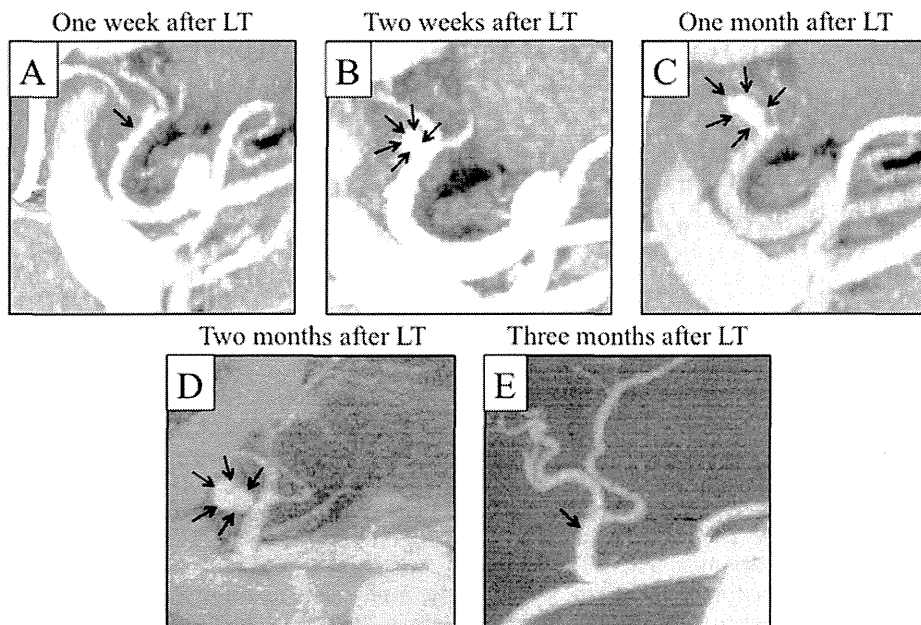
Development of a hepatic artery pseudoaneurysm as observed with dynamic computed tomography after LT. (A) One week after LT, there was no hepatic artery aneurysm. (B) Two weeks after LT, a tiny globular pseudoaneurysm was evident at the distal side of the anastomosis. (C) One month after LT, the pseudoaneurysm was developing as a spindle-shaped form. (D) Two months after LT, the pseudoaneurysm had grown to 7 mm in diameter. (E) Three months after LT, the hepatic artery pseudoaneurysm spontaneously disappeared (10 days after a pause in the anticoagulant administration).
